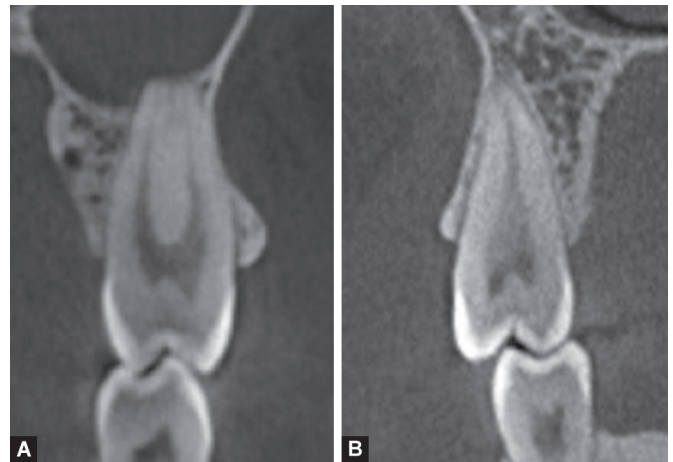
CBCT sagittal slides of maxillary second premolars showing; (A) one-rooted 2nd premolar with 2 canals and Vertucci type IV, (B) second premolar with one root, one canal, and type I Vertucci
